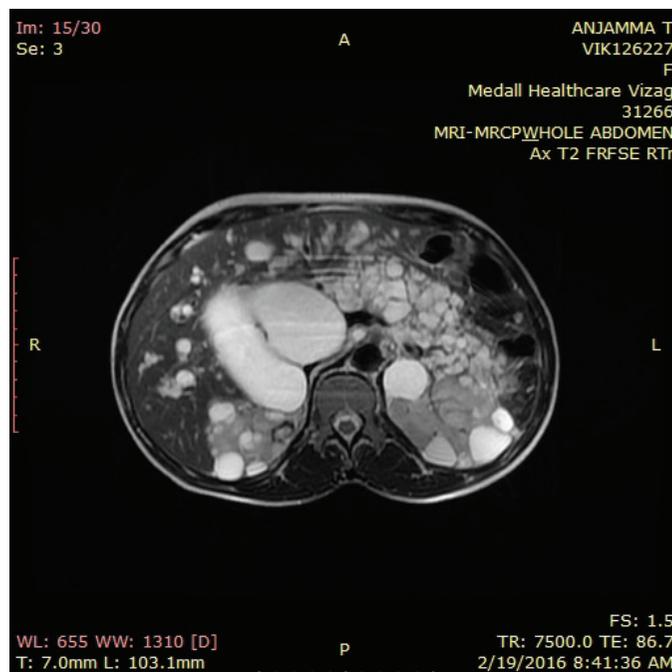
MRI abdomen showing dilated bile duct, cysts in pancreas and kidney.
